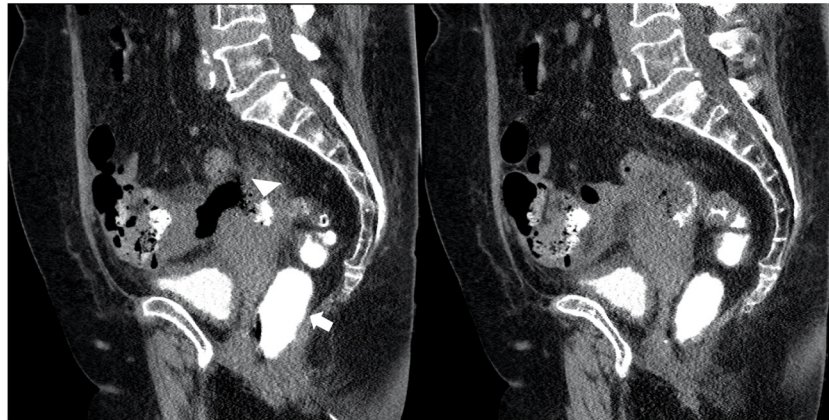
Sagittal computed tomography scan with rectal contrast demonstrating a rectal stump leak with passage of contrast from the rectum (arrow) into the adjacent collection (triangle).
